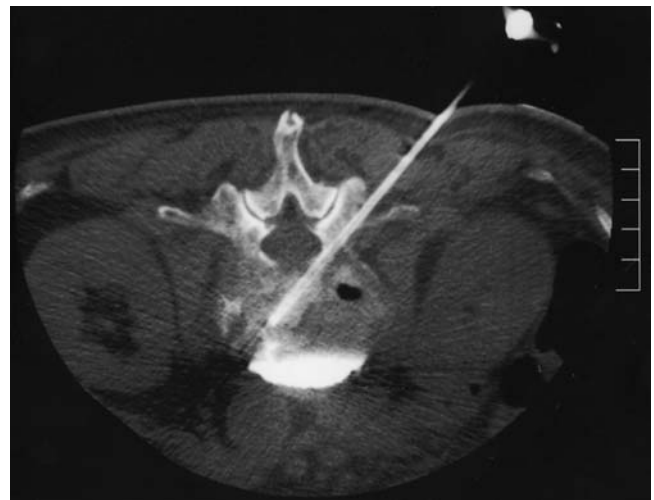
Computed tomography (CT) during percutaneous vertebroplasty (PVP) in Case 1 showing the puncture needle and bone cement injected into the L2 vertebral body
